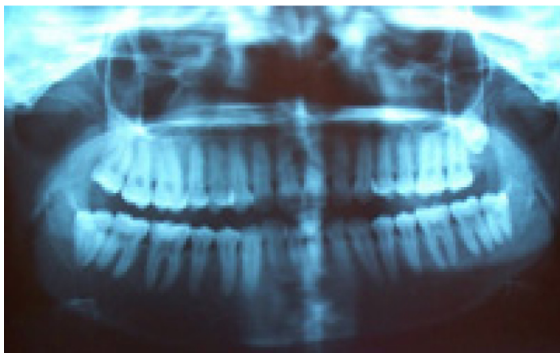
Panoramic radiograph showing no odontogenic origin in relation to the swelling.
